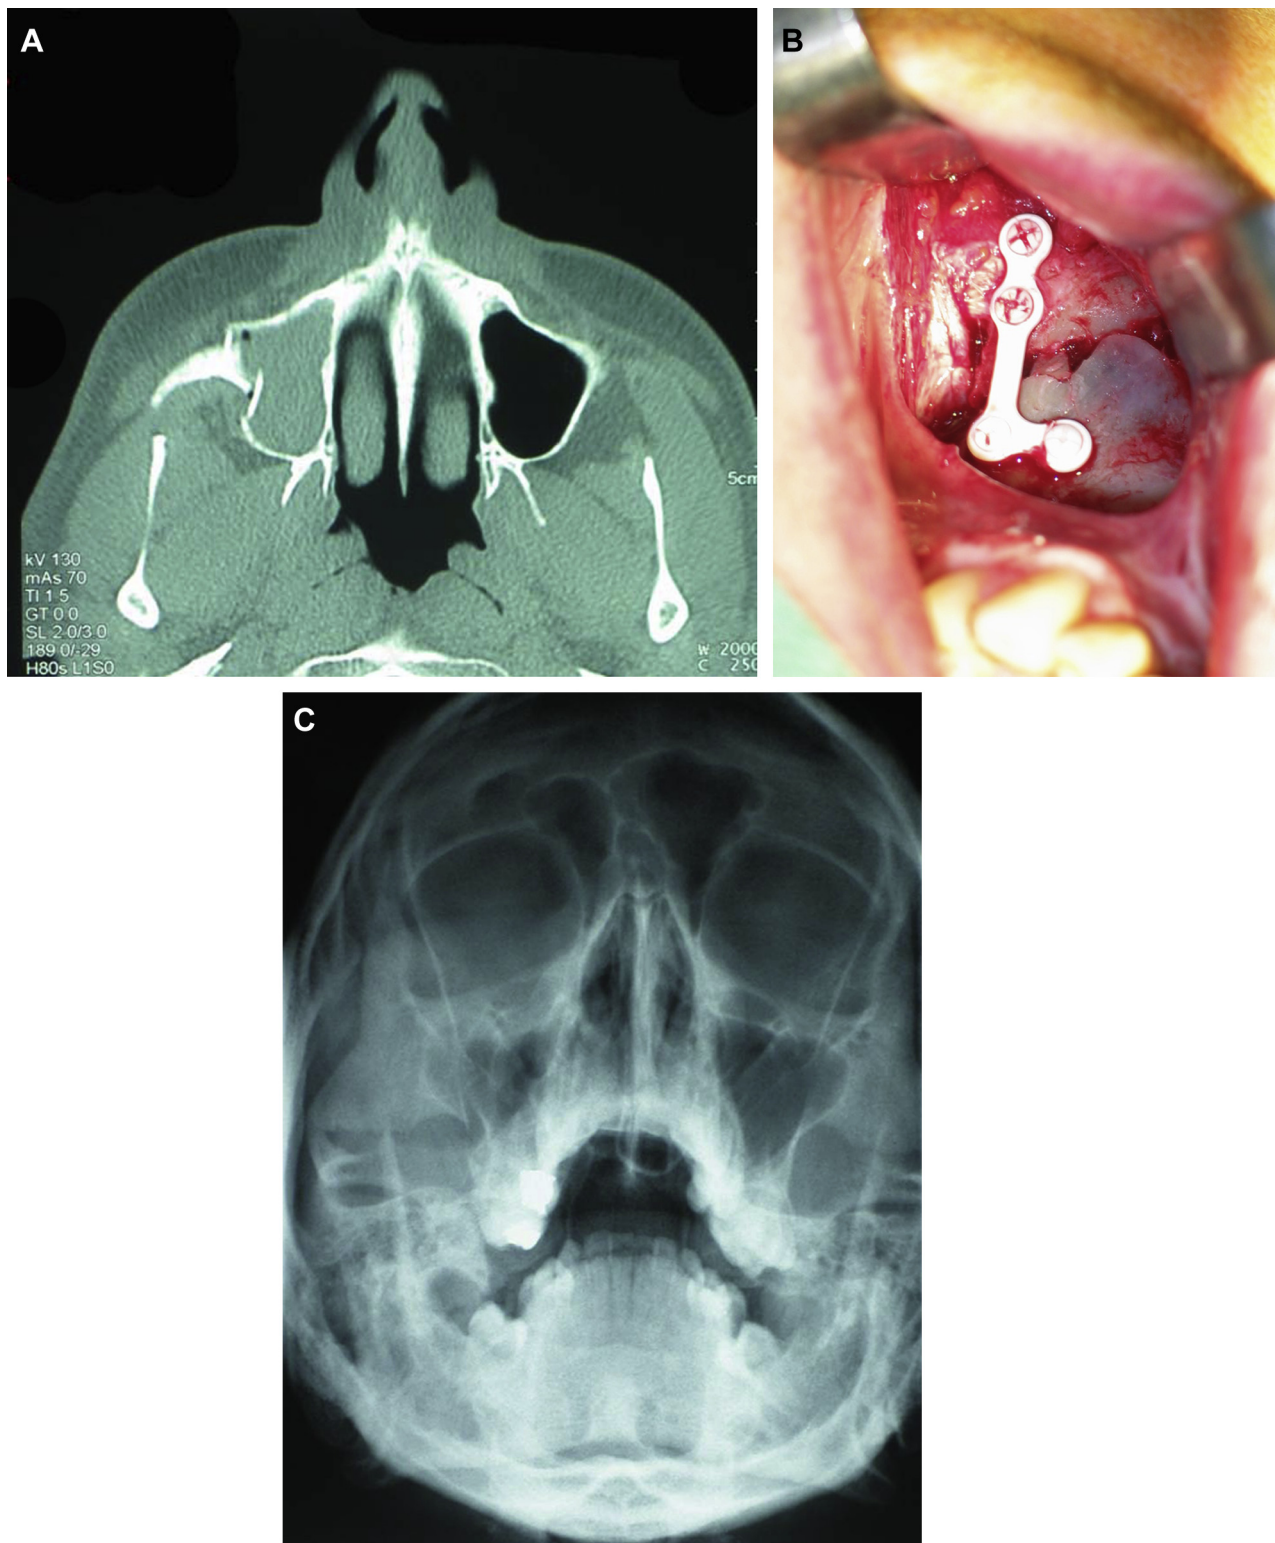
An 18-year-old male patient with a right malar fracture from a sports injury. A, Computed tomography scan of the right malar fracture. B, Intraoperative appearance after fracture reduction using a transoral vestibular margin incision and internal fixation with a 4-hole L-plate with 6-mm screws. C, Water projection radiograph at 1 day postoperatively showing satisfactory reduction and fixation.
